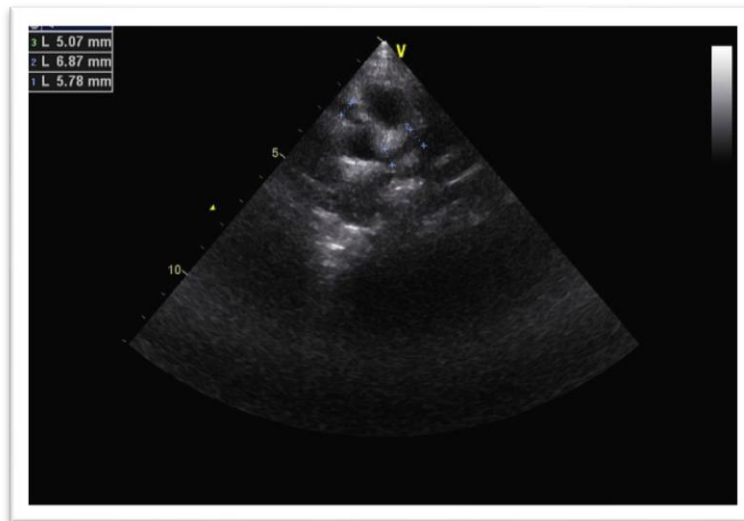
Echocardiogram revealed prominent dilated coronaries with perivascular brightness involving LMCA, LAD and LCX suggestive of Kawasaki disease
